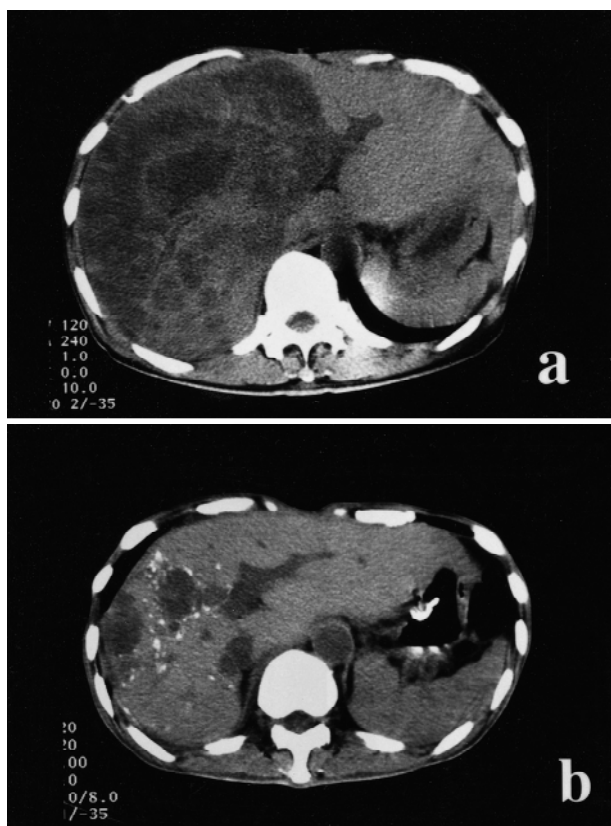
CT images of case 1 before (a) and after (b) hepatic arterial infusion. Almost all the right lobe was occupied by metastatic tumors (a). The reduction of tumor lesions was more than 90% 4 months after initiation of the therapy. High-density spots suggesting calcification were seen around the residual tumors (b)
